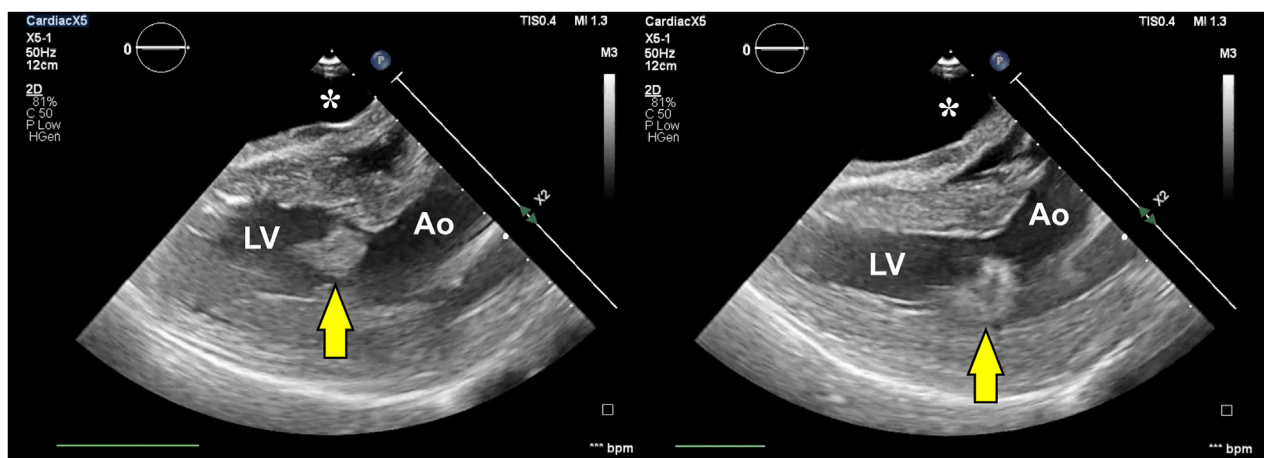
Two-dimensional epicardial echocardiography (day 16, after CPB initiation), left ventricular long-axis diastolic (left) and systolic (right) displays, demonstrates a thrombus (arrows) dislodged into the LVOT. The anterior echo-free space represents the placement of a fluid-filled bag (asterisk) between the echocardiographic probe and the heart to allow optimal imaging. Ao, Aorta; LV, left ventricle.
